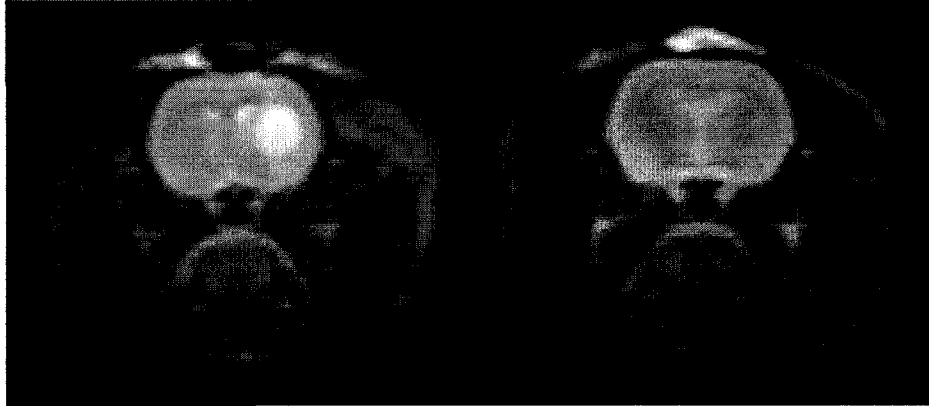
T2w, T1w-pre and -post contrast enhanced MRI images acquired 1 day following PDT. Due to its high water content, edema appears hyperintense (bright) on T2w images and hypointense (dark) on T1w images. Contrast agents were administered 15 min. prior to scans in order to determine BBB disruption. The appearance of enhancement on T1w images following contrast administration suggests BBB disruption.
